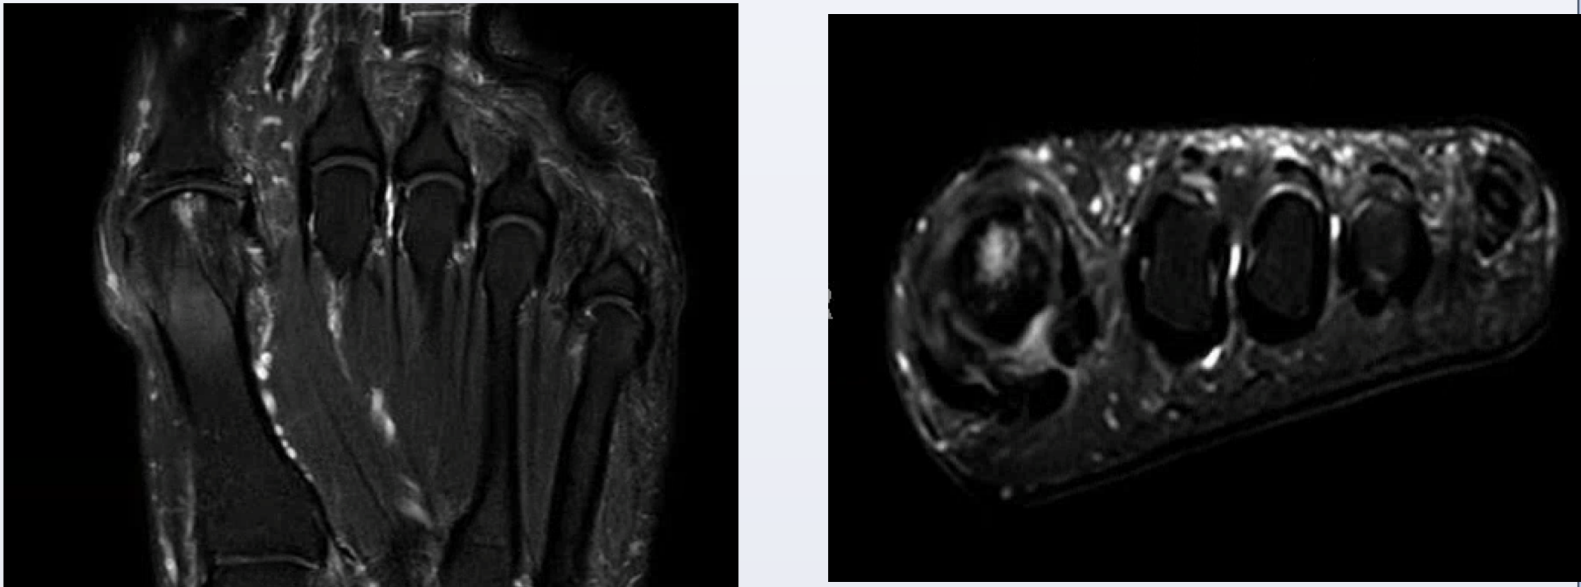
Pre operative MRI of patient 3 showing a 0.5 cm in diameter by 0.2 cm deep lesion in the central metatarsal head.
